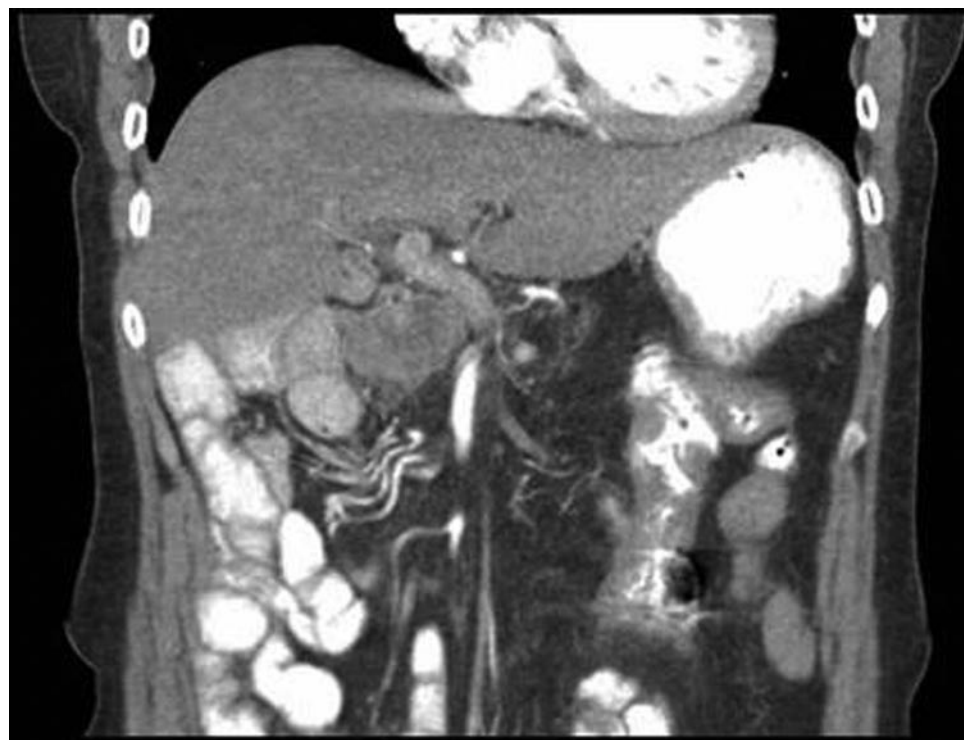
CT image demonstrating nonrotation with the small bowel located in the right abdomen and large bowel in the left abdomen. Small bowel mesenteric vessels are also seen, highlighting their anomalous positioning.
